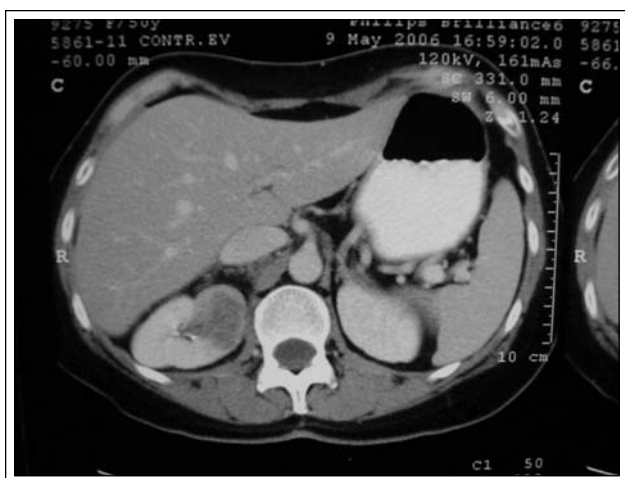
Abdominal CT showing lesion in the right kidney.
